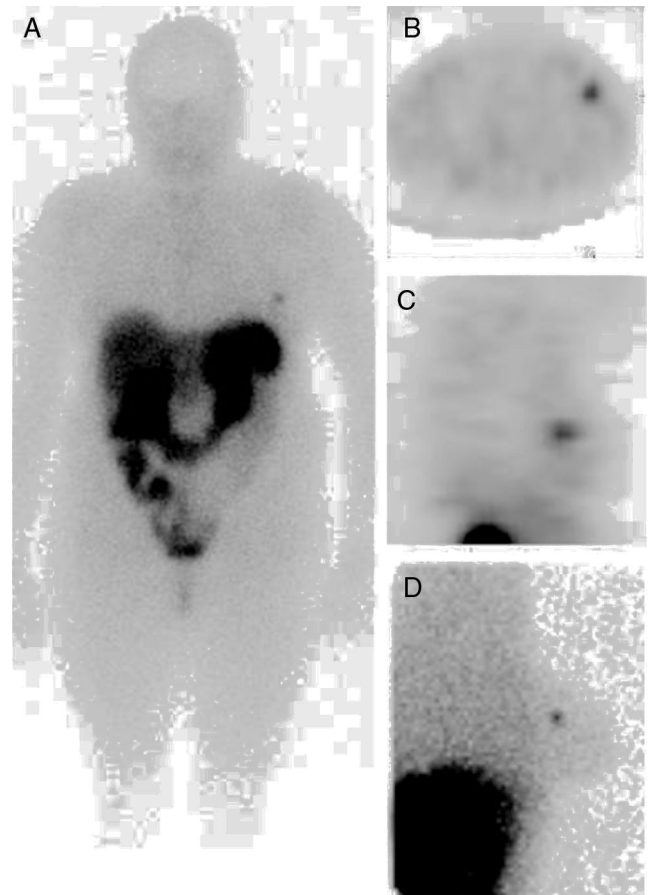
Whole-body (A), SPECT (axial view [B], sagittal view [C]) and left lateral planar in prone position (D) images identified a focal increased uptake in the left breast.
